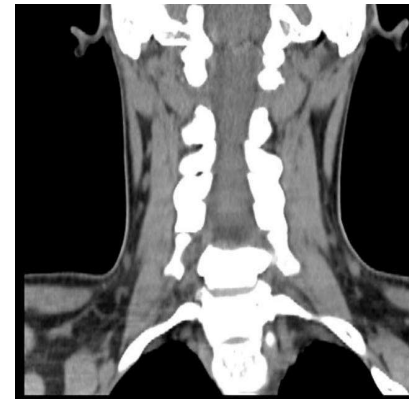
CT of the cervical vertebra shows bilateral cervical ribs
